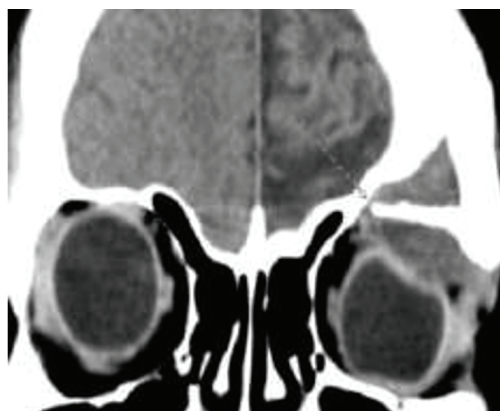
CT image shows the presence of an orbital roof fracture with a pseudomeningocele, extending into the extraconal space of left eye.
